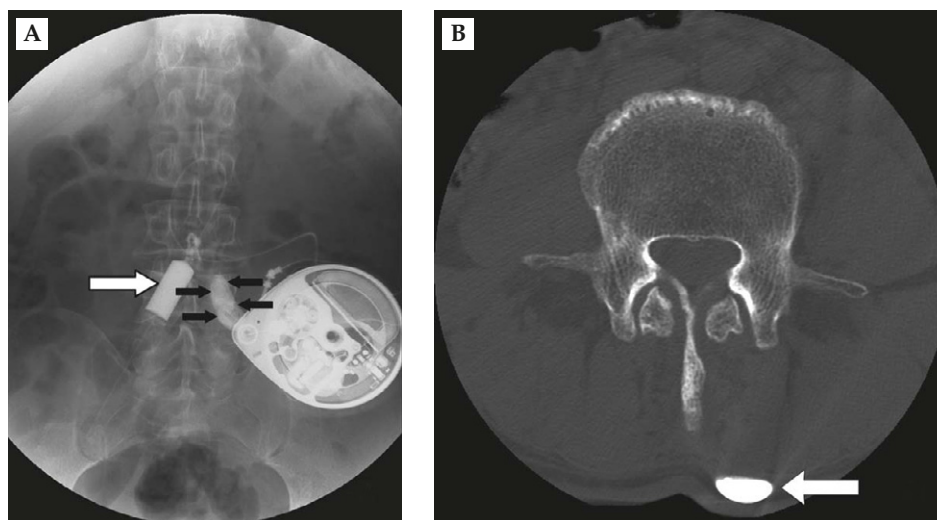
(A) X-ray evaluation of the catheter system with contrast medium accumulating outside of the intrathecal distribution in the lumbar paraspinal region (black arrows). The syringe used to introduce the contrast via the side port of the pump is indicated (white arrow). (B) Computed tomography further demonstrates the accumulation of contrast medium in the subcutaneous layers (white arrow).
